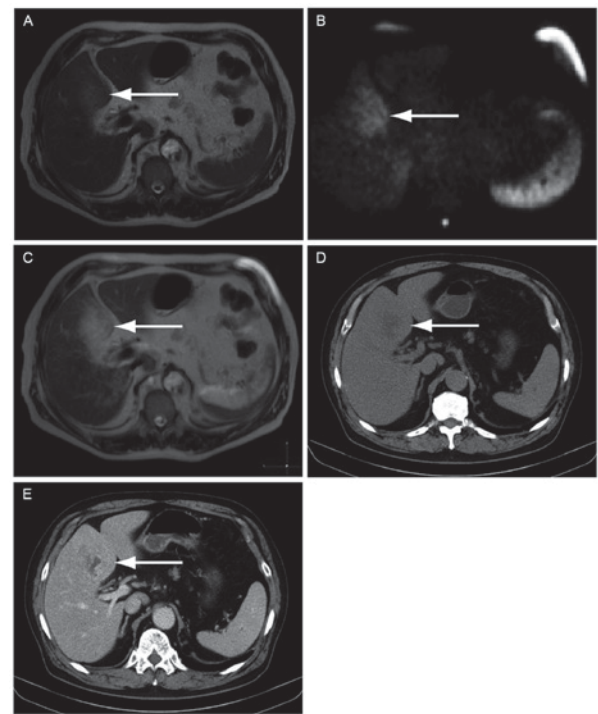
Liver inflammation due to acute cholecystitis. (A) A T2-weighted image of a 70-year-old man with acute cholecystitis found a weak high signal intensity in the liver. (B) High signal intensity was observed in the liver with DWIBS. (C) The fusion image of T2-weighted images and DWIBS clearly showed the high signal intensity in the liver. (D) Plain CT scanning identified an irregularly shaped, low-density area in the liver. (E) The low-density area became more obvious with contrast-enhanced CT. Arrows indicate the area of liver inflammation. All the figures were representative of the participants in the present study. DWIBS, diffusion-weighted whole body imaging with background body signal suppression; CT, computed tomography.
